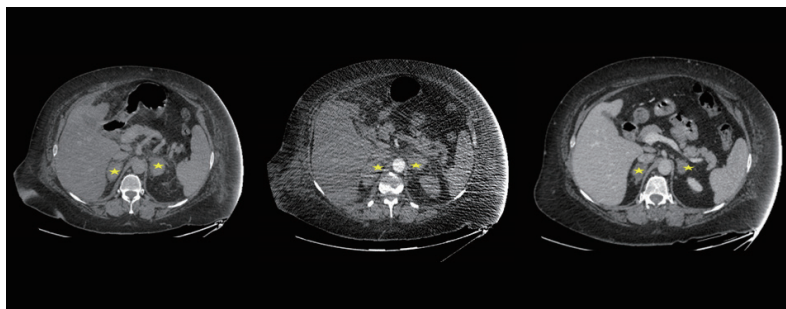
Computed tomography revealed bilateral adrenal hemorrhage (yellow star) complicating laparoscopic cholecystectomy.
